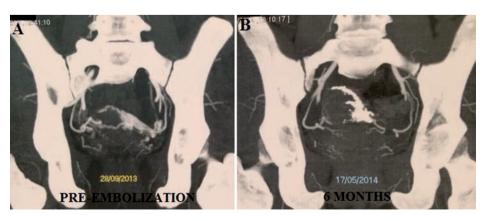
A: Pre-embolization CT angiography demonstrating the hypervascularization at the left side of the uterus and the uterine fundus, originating from the left uterine artery. (B) Hypervascularization reduction after embolization.
